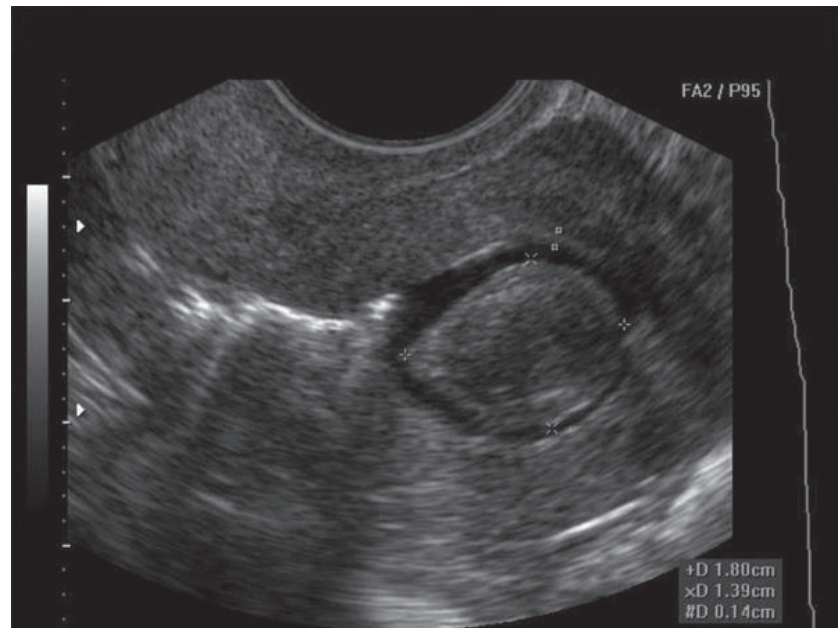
Saline Ultrasonography Demonstrating an Intracavitary Leiomyoma
